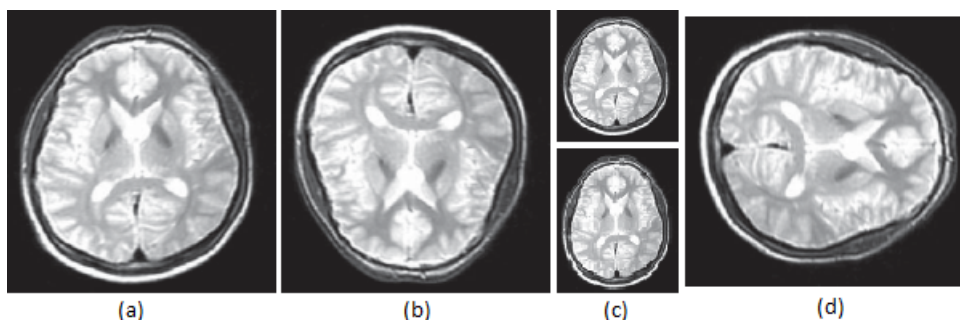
Example of affine transformations applied to a brain magnetic resonance image. Respectively: (a) original image (b) vertical flipping (c) scaling (d) horizontal flipping
